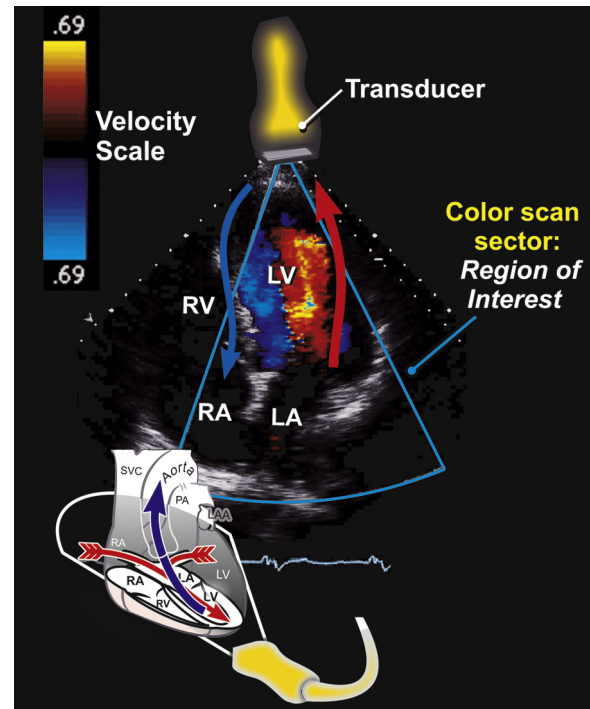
Color flow Doppler. By convention, blood flow moving toward the transducer is color-coded red and flow away from the transducer is shown in blue. The color velocity scale (upper left vertical bar) represents increasing velocities in either direction, with higher velocities depicted in progressively brighter hues. Note the Nyquist limit (69 cm/sec) displayed above and below the color scale bar. Velocities greater than the Nyquist limit cause aliasing, i.e., an apparent wraparound in the color-coding to that of the opposite direction. LA, Left atrium; LV, left ventricle; RA, right atrium; RV, right ventricle. (Modified from Bulwer BE, Rivero JM, eds. *Echocardiography Pocket Guide: The Transthoracic Examination*. Burlington, MA: Jones & Bartlett Learning; 2011, 2013:156. Reprinted with permission.)
